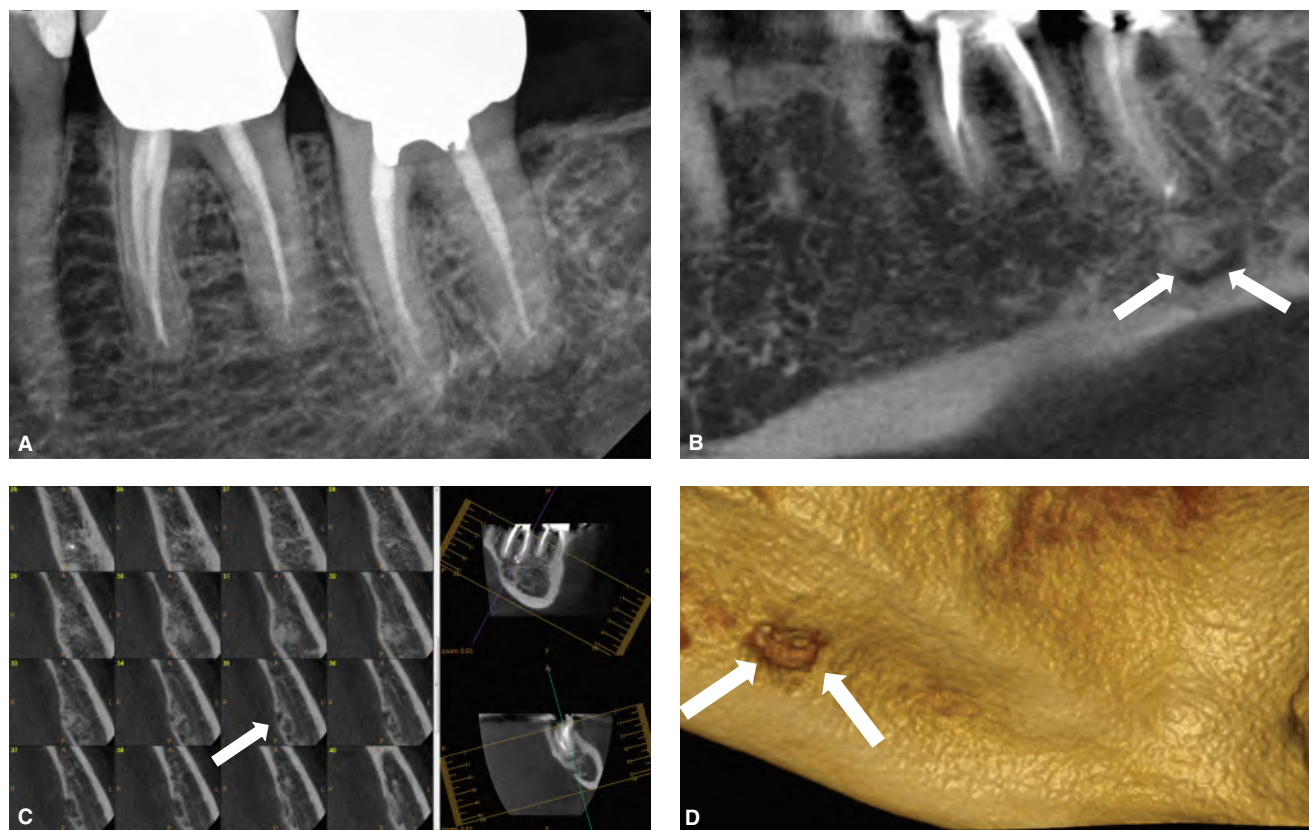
5 Outcome predictors based on intraoral radiography and CBCT vary. A. Periapical radiograph shows previous incomplete endodontic treatment of an asymptomatic mandibular left second molar. There are short metal posts in the mesial and distal roots, and an area of low radiodensity at the furcation that extends to the distal aspect of the distal root. B. CBCT panoramic reformation shows a periapical discontinuity of the lamina dura and widening of the PDL space, with periapical osseous rarefaction that appears to track along the distal aspect of the mesial root in a narrow channel, to a large region of low radiodensity at the furcation, and also appears to track inferiorly to a 6-mm diameter somewhat well-defined serpiginous defect (solid arrows), causing erosion of the lingual cortex. C. CBCT-correlated multiple cross sections show two unilocular regions of low attenuation with well-defined, corticated borders constituting a multilocular lesion lying along the lingual cortical plate (solid arrow). D. 3-D reformation of the same area shows erosion of the cortex (solid arrows).
